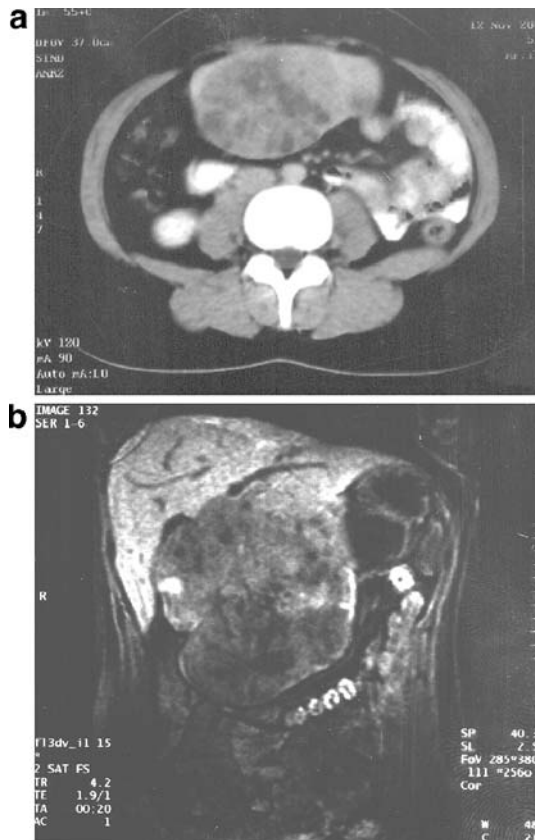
Radiographic findings: a Abdominal CT scan showing a well-circumscribed tumor mass in the left hepatic lobe. b MRI of the abdomen: on fat saturation images, the tumor appears multilobulated and inhomogeneous, with focal cystic changes
